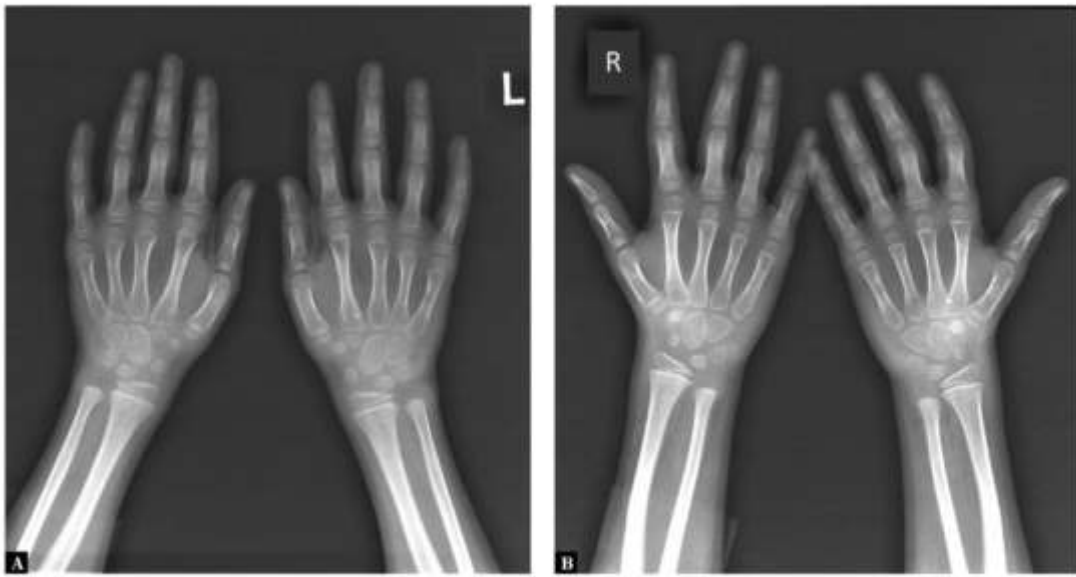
AP (A) and oblique (B) radiograph of the hands in a 6-year-old girl: periarticular osteoporosis of the hands, periosteal build-up/thickening along the 2nd and 3rd distal phalanges of both hands
